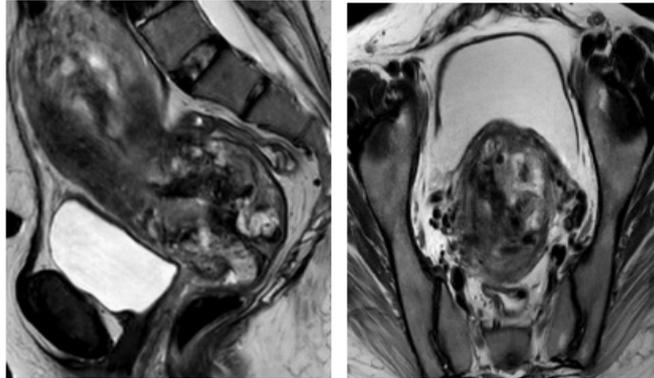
The T2-weighted imaging showed variable signal intensities including hyperintense and hypointense areas.
